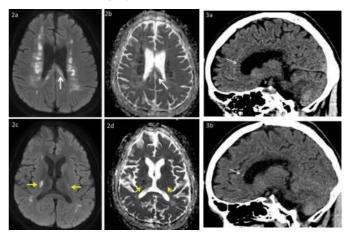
MR images showing striking restricted diffusion in the white matter lesions bilaterally involving splenium of the corpus callosum (white arrows).
